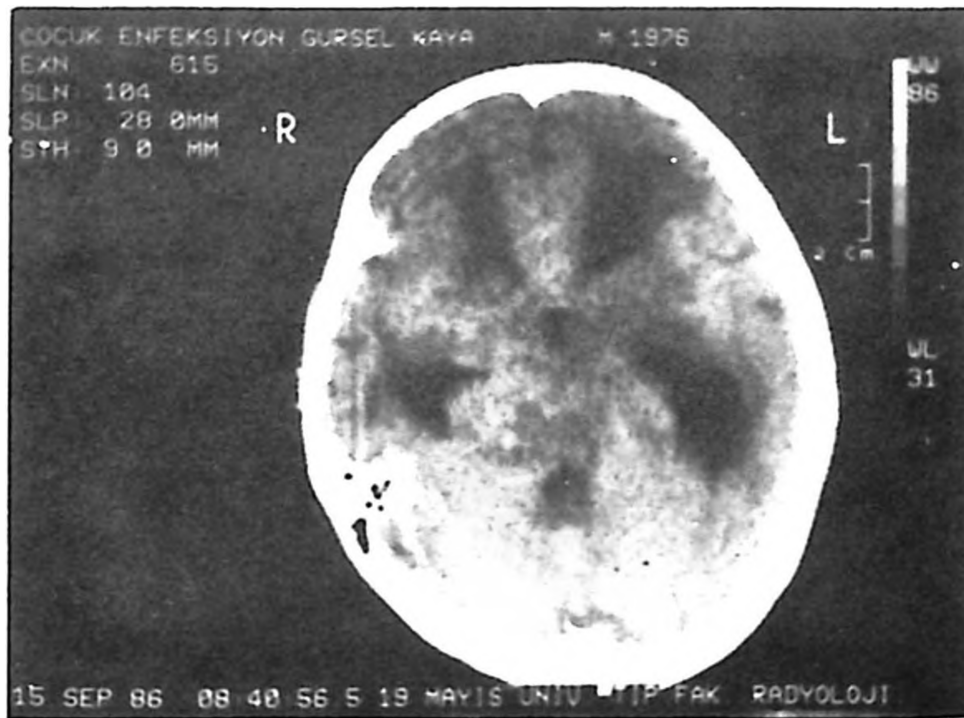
Precontrast CT study of Case No. 3 shows marked dilatation of the ventricular system and obliterated basal cisterns.
